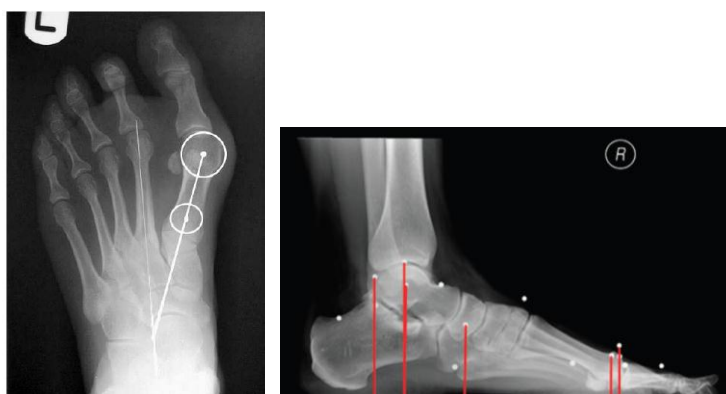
Radiographic measurements used to classify the foot arch.
